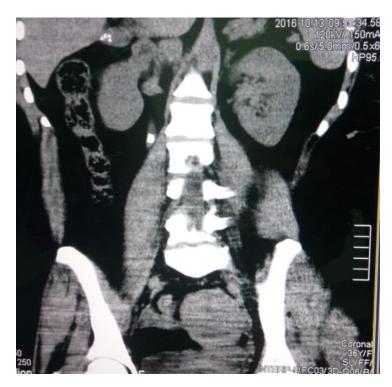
Figure (A-4) CT-KUB coronal section, soft tissue window, right upper uretic stone
